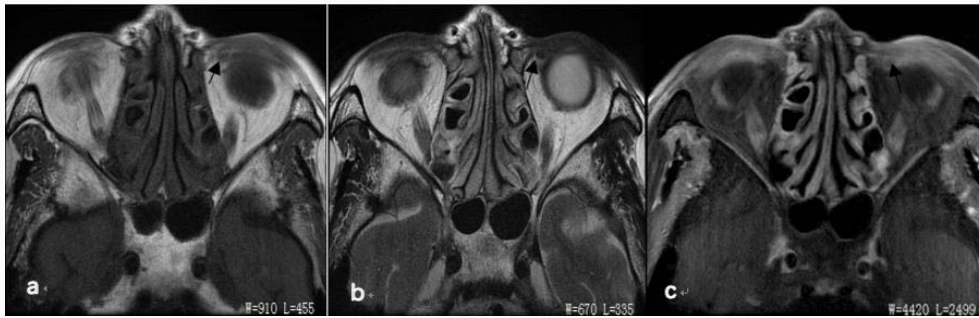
MRI image of orbit (Transverse section).
